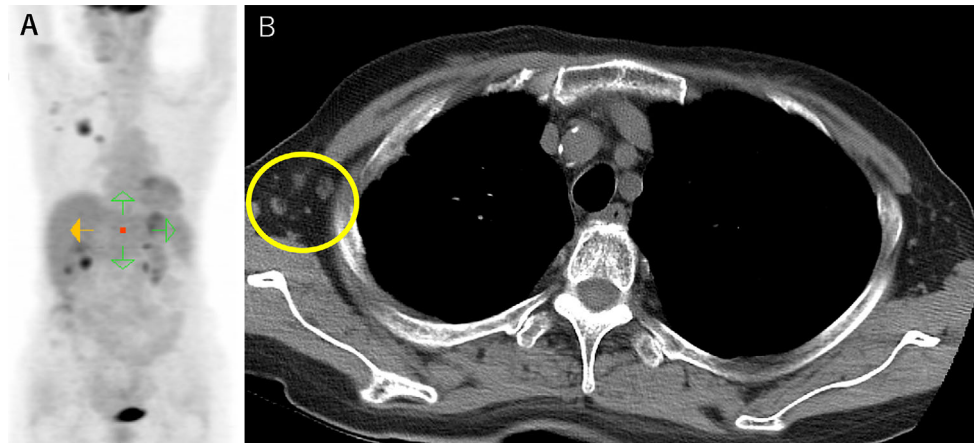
Images of Patient 1. (A) FDG PET-CT (maximum intensity projection image) revealed a high FDG uptake in the right upper lobe (primary tumor), right axial lymph nodes, and right hilar lymph nodes. (B) Cortical thickening of the lymph nodes in right axilla (yellow circle) was detected.
